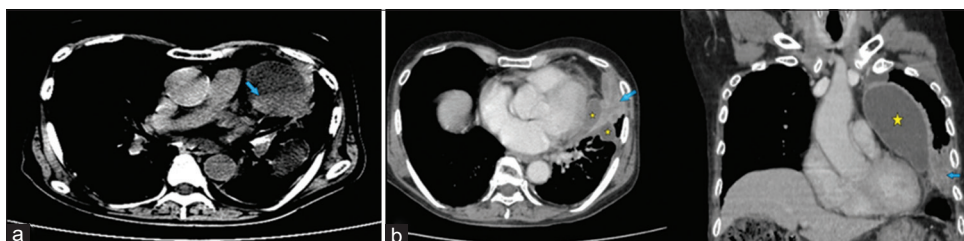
(a) Non-contrast axial computed tomography (CT) thorax on appropriate windowing showing settled hyperdense content within the cystic cavity representing settled debris (blue arrow); (b) Axial and coronal sections of contrast-enhanced CT thorax demonstrating a heterogeneously enhancing lesion in inferior lingular segment (blue arrow) in contact with both the loculated fluid collections (yellow stars)
